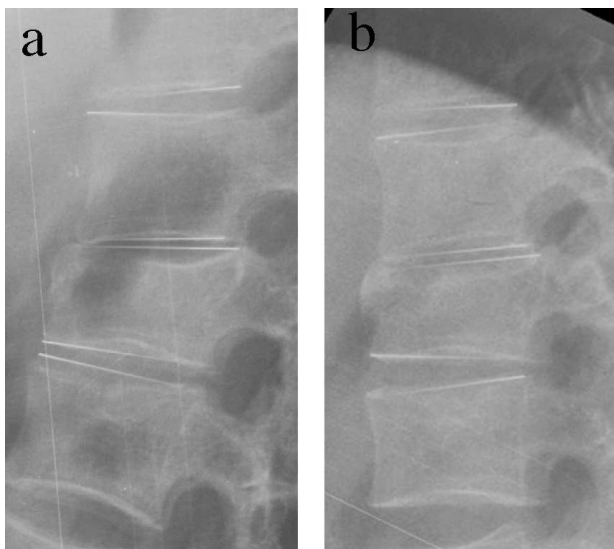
Thoraco-lumbar X-ray, in maximum flexion and extension in a patient with L1 fracture after removal of instrumentation. It is possible observe a normal ROM in the upper and lower disc, but a ROM reduction in the fractured vertebra disc.
